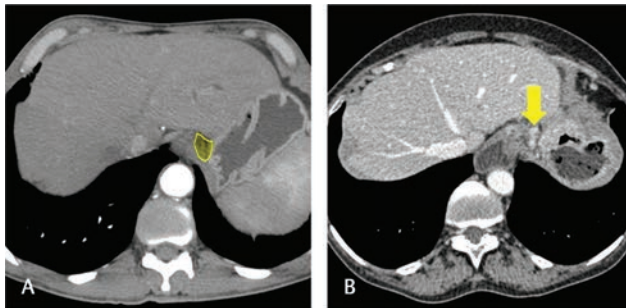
Station 2. Axial computed tomography images in arterial (A) and venous (B) phase. The esophagogastric branch of left subphrenic artery (yellow area) is seen in (A) along which lie the left paracardial nodes (yellow arrow in B). Gastric wall thickening can also be seen in (B).
